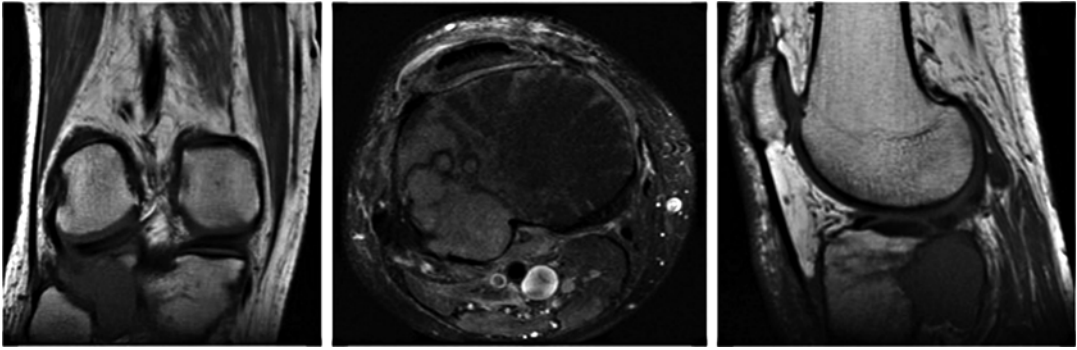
Fifty-four year-old male with metastatic non-small cell lung adenocarcinoma. MRI demonstrating focal area in posterolateral tibial plateau, with involvement of the tibial articular cartilage
